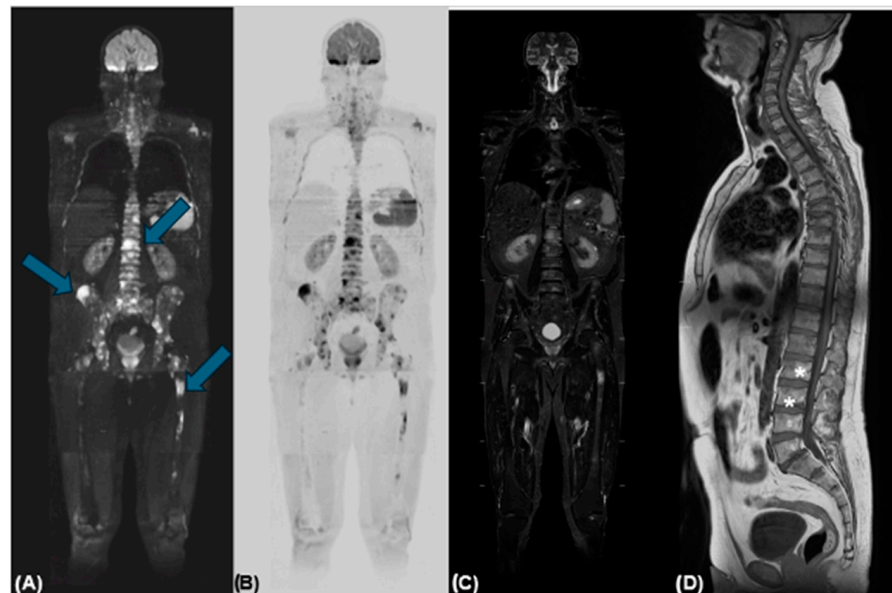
Figure shows the most representative sequence of the 1.5 T whole-body MRI. (A) A coronal reconstruction of diffusion-weighted imaging (DWI) with restricted diffusion of the bone lesion (blue arrows) at high b-values; (B) Image represents a high b-value DWI with inverted grey-scale PET-like reconstruction of the bone lesions. (C) A coronal short tau inversion recovery (STIR) that enhances bone substitution with a hyperintense signal compared to the adjacent fatty bone marrow. (D) Image represents a sagittal turbo-spin-echo (TSE) sequence where the bone lesions appear as focal hypointense alterations (asterisks).
